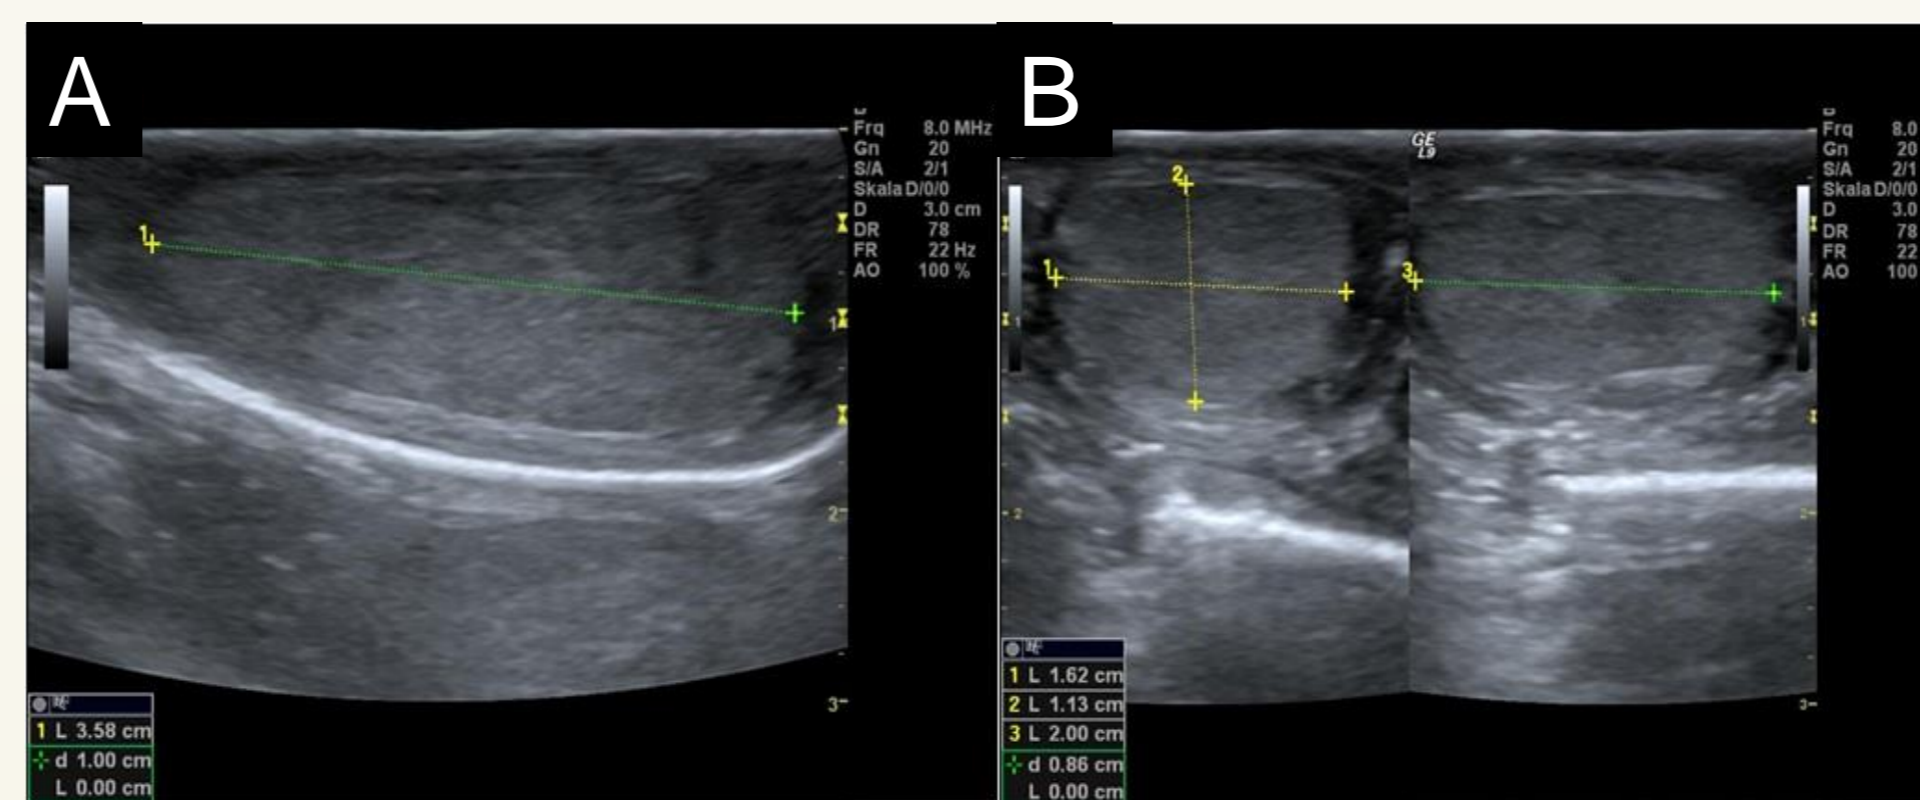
Testicular ultrasound. A. longitudinal section of the left testicle: macroorchidism (10ml) and inhomogeneous structure. B. Transversal (*left*) and longitudinal (*right*) section of the right testicle: pubertal size (6ml) and normal structure
